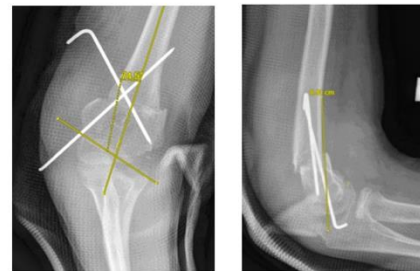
Post-operative plain radiographs showed Baumann angle corrected to 74.5 degree and AHL passed through the capitellum.
